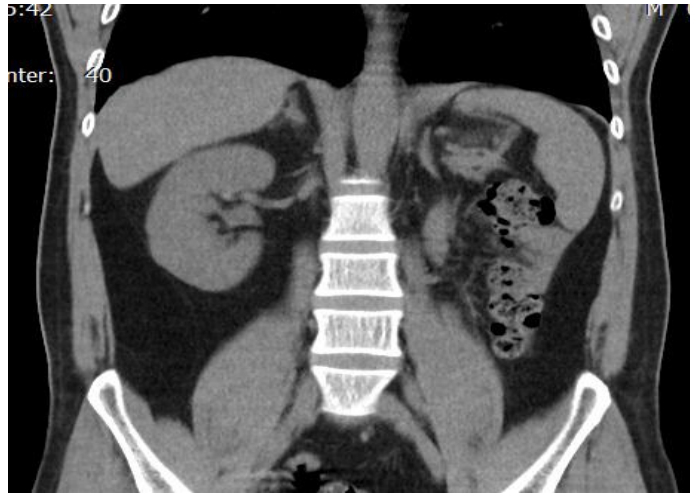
Abdominopelvic CT showing absence of left kidney
